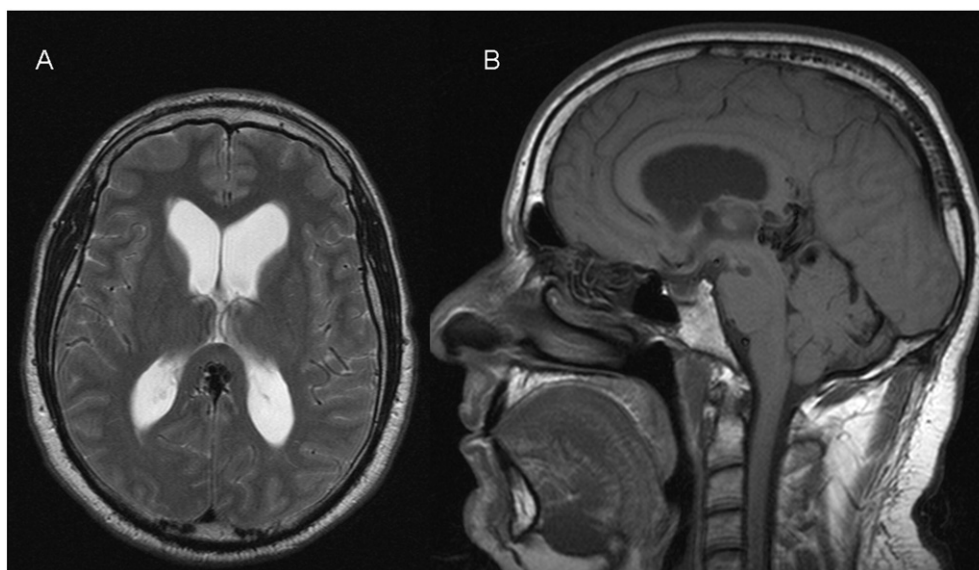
MRI upon presentation. MRI = magnetic resonance imaging, DSA = digital subtraction angiography. Panel A: Axial T2 image displaying enlargement of the lateral ventricles, consistent with hydrocephalus. Large flow void can be seen in the area of the quadrigeminal cistern. Panel B: Sagittal T1 image displaying enlargement of the lateral and third ventricles. Arteriovenous malformation seen within the tectum, with dilated vein of Galen.
